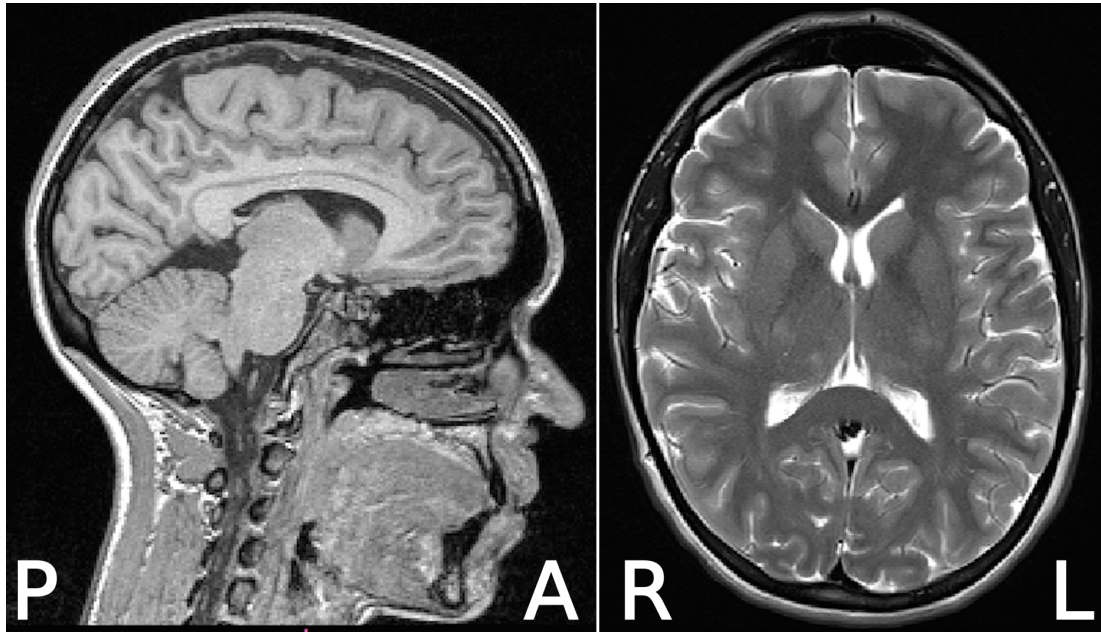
T1- and T2-weighted images of a healthy 24-year-old female. Left panel shows a T1-weighted (Fast Low-Angle Shot; FLASH) spoiled gradient echo sequence. Right panel shows a T2-weighted (turbo spin echo sequence).
